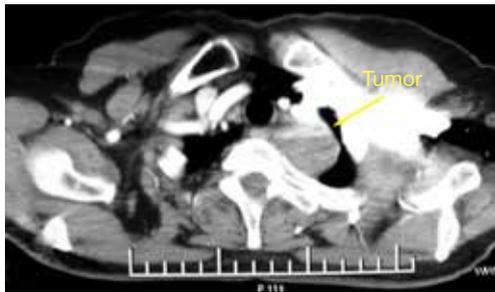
Chest CT shows a mass at the top of the left posterior superior mediastinum.
